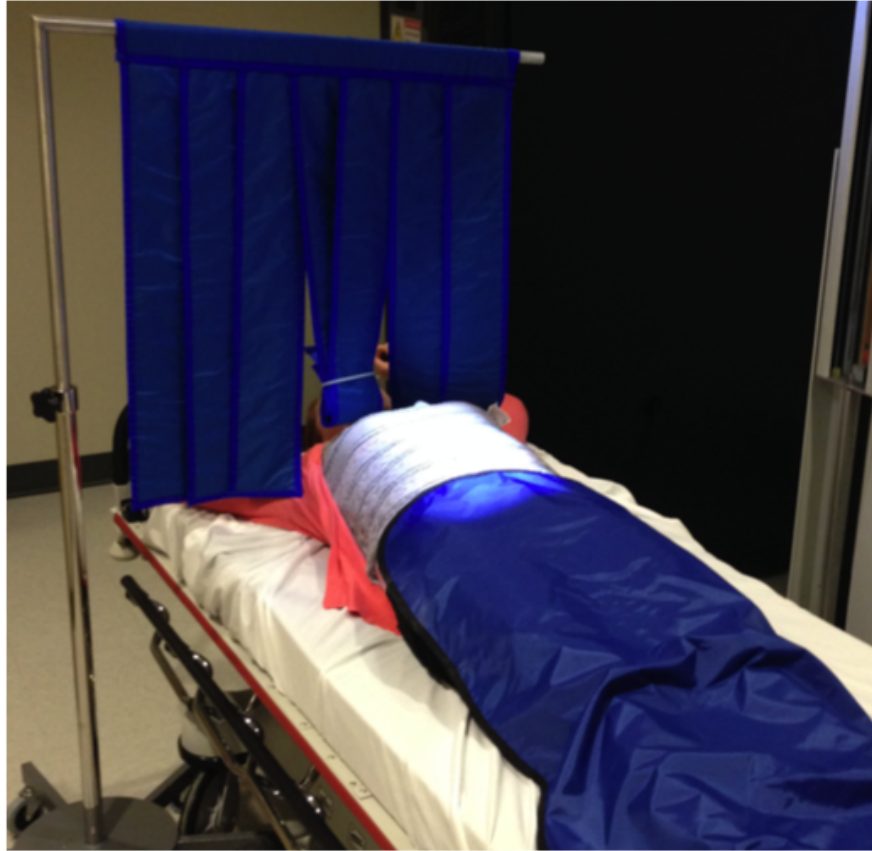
A photo demonstrating the radiation shielding on the patient side. The head shielding protects the patient's head from unnecessary x-ray exposure. The lead apron protects the patient's lower body.
